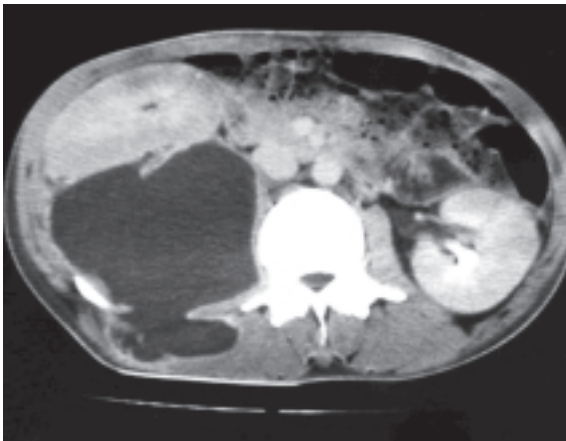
Primary psoas abscess in a 37-year-old HIV-positive man. Enhanced axial CT scan shows a large abscess in the right psoas muscle with extension to the right paravertebral muscles. The right kidney is anteriorly displaced. Drainage was performed, and *Staphylococcus aureus* was cultured.
